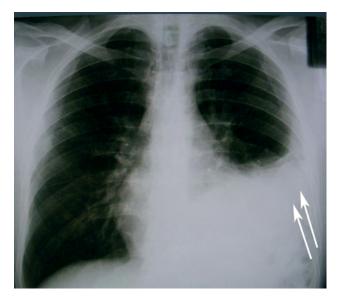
Conventional chest X-ray of patient with left Bochdalek hernia. The changes in the left half of the chest are interpreted as left pleural effusion (white arrows).
